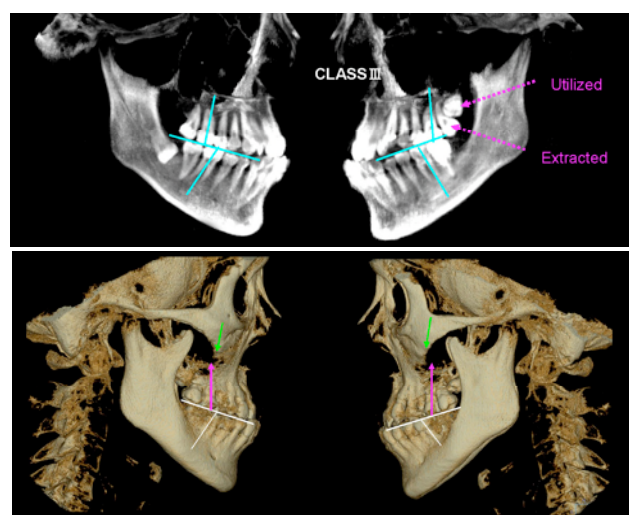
1 CT image at pre-treatment and post-treatment
